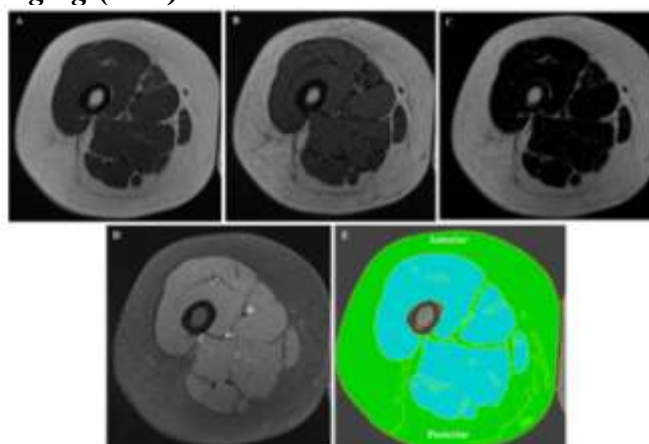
Dixon MRI sequence of the thigh of a 62-year-old female patient. (A) axial T1WI in phase, (B) out phase, (C) 100% fat images, (D) 100% water images. After post-processing, a semi-automatic segmentation was obtained (E) showing fat (green) and muscle (turquoise) separately in one slice 3.(Chianca et al., 2021).
